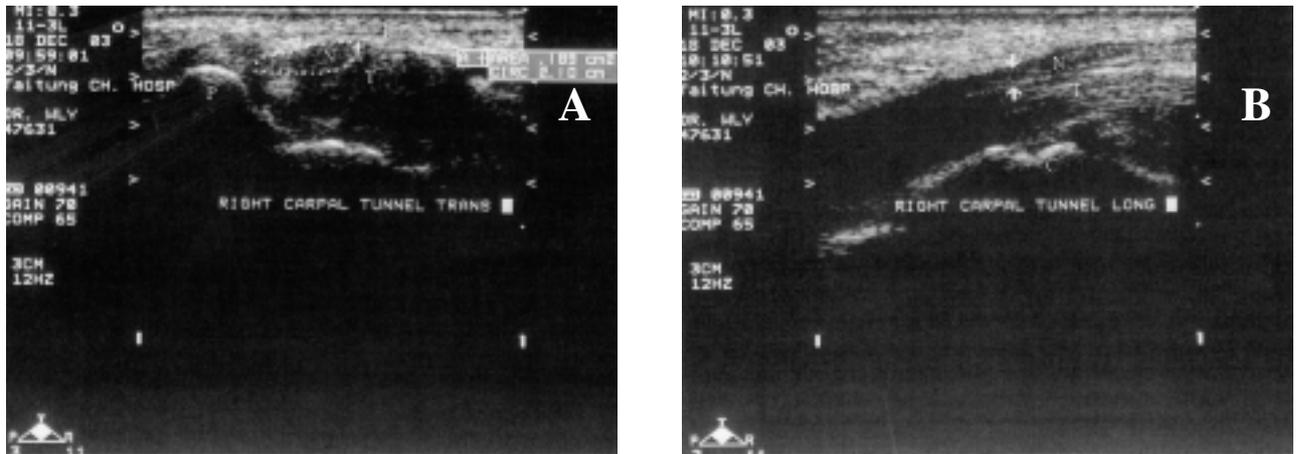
Ultrasonography of carpal tunnel syndrome (patient 17). (A) Increased cross-sectional area of the median nerve (N) at the level of the pisiform bone (P) on a transverse scan. (B) The median nerve (N) compressed (between the arrows) by the thickened transverse carpal ligament (L) on a longitudinal scan.
